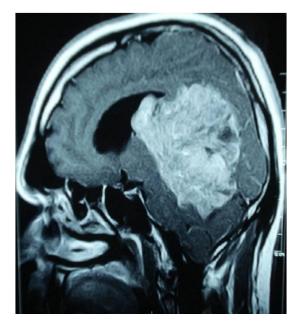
Post contrast MRI MRI showing contrast enhancing heterogeneous lobulated mass in pineal region.
